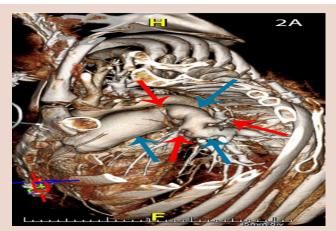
Volume rendered CT angiogram of the chest shows a tortuous left pulmonary artery and upper lobe branches with multifocal stenosis (red arrows) and aneurysms (blue arrows).
